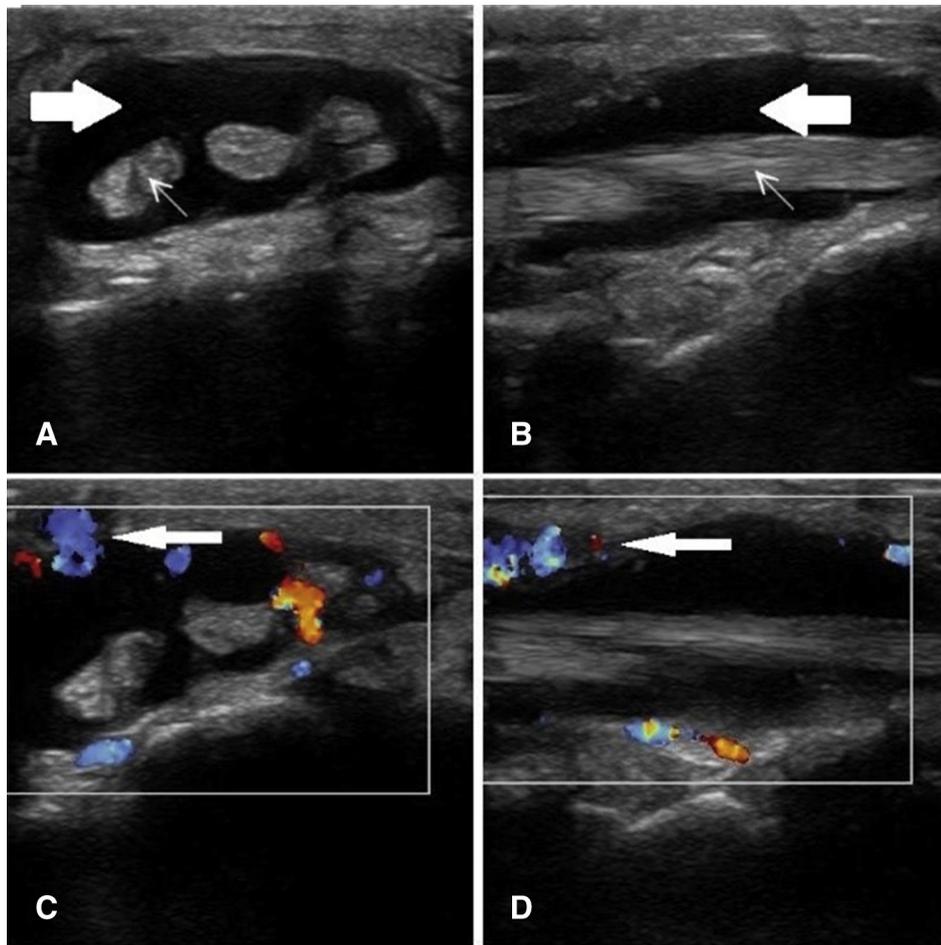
Ultrasonographic images of the patient's dorsal right wrist using a linear probe (L10-5 probe using the Zonare Z.One Pro Ultrasound System): (A) Transverse view of the dorsal wrist detailing the extensor tendons (small arrow) surrounded by fluid (large arrow) within the tendon sheath. (B) Longitudinal view of the dorsal wrist detailing a tendon (small arrow) bathed in fluid (large arrow) within the tendon sheath. Color Doppler in both transverse (C) and longitudinal (D) orientations highlights areas of increased flow in the surrounding tissue (arrows), but is largely absent in the tendon sheath effusion.
